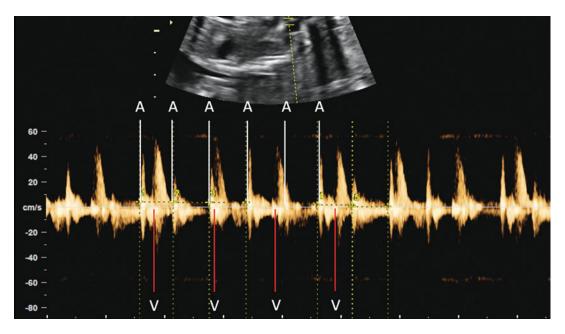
Complete heart block demonstrated using an SVC/Ao Doppler tracing. The atrial contractions (*A*) occur at a regular and normal rate while the ventricular
